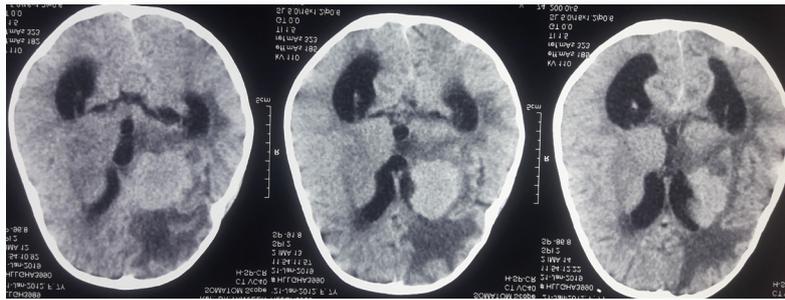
CT scan showing space occupying lesion in left basal ganglia and left medial temporal lobe with surrounding edema, dilated lateral ventricles and meningeal enhancement
